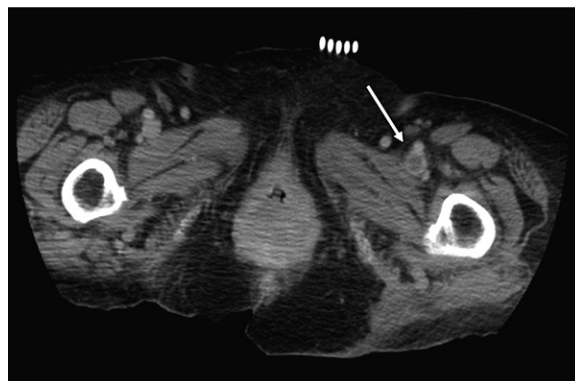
Incidental DVT in an emergency department patient with right upper quadrant pain. Axial contrast-enhanced CT image of the abdomen and pelvis shows an incidental left common femoral DVT (arrow).
